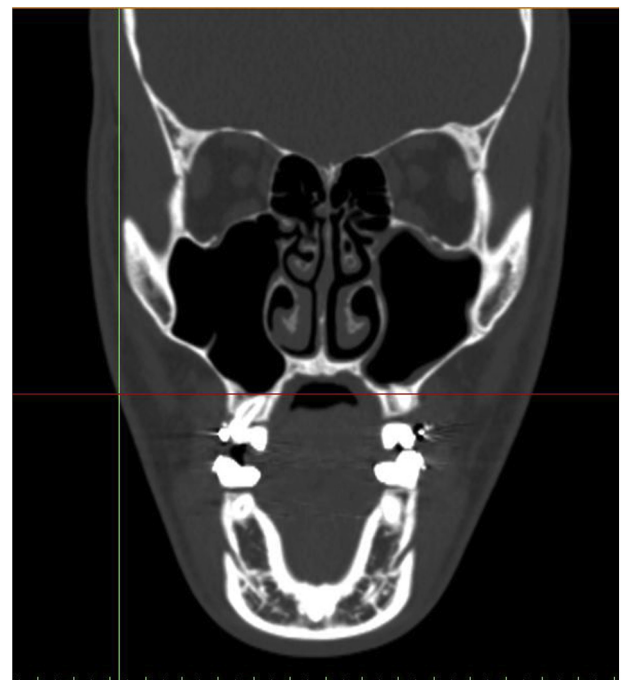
Preoperative coronal computed tomographic image.
